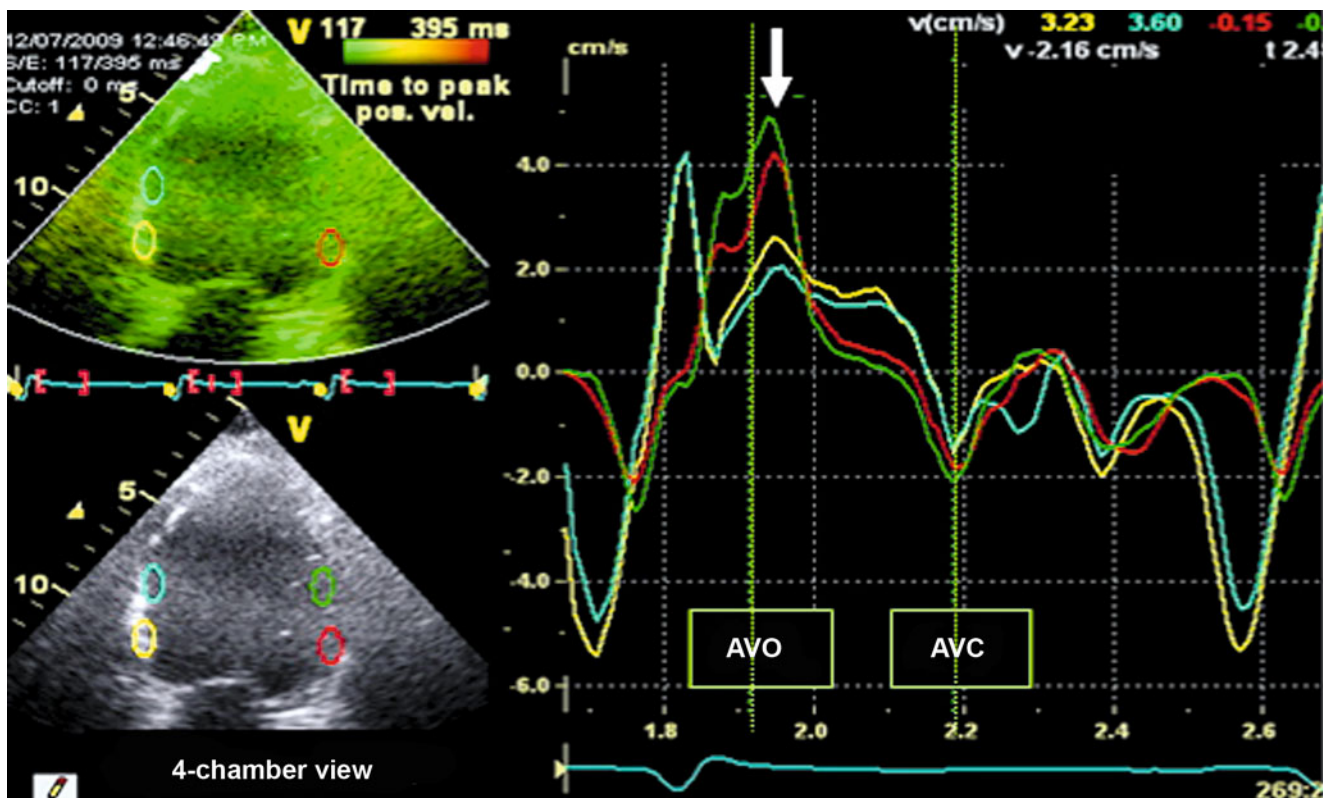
A representative example of a patient with significant QRS widening 150 ms, but no significant dyssynchrony using tissue Doppler longitudinal velocities. Note that the time-to-peak velocities are similar in the three apical views. This patient was a non-responder to cardiac
